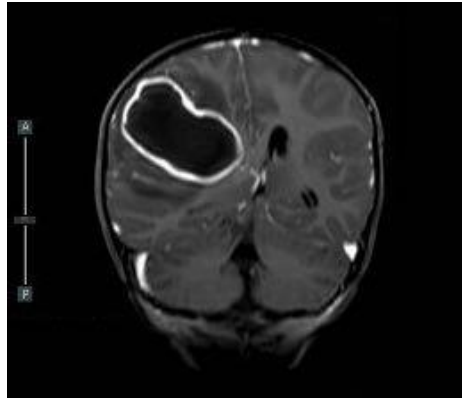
Cranial MRI with gadolinium contrast showing cerebral abscess
